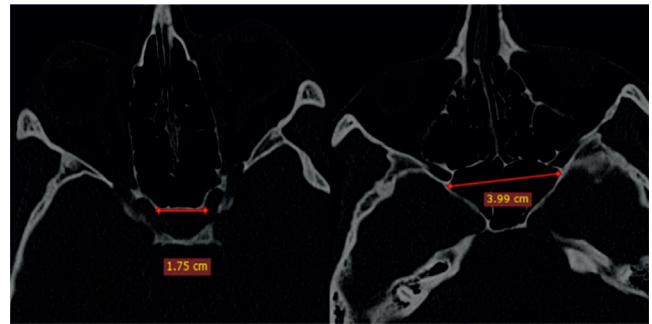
Transaxial CT images (Bone window) through sella (left) showing measurement of presellar width of sphenoid sinus just in front of sella turcica (anterior sellar wall) and sphenoid sinus (right) showing its maximum width
